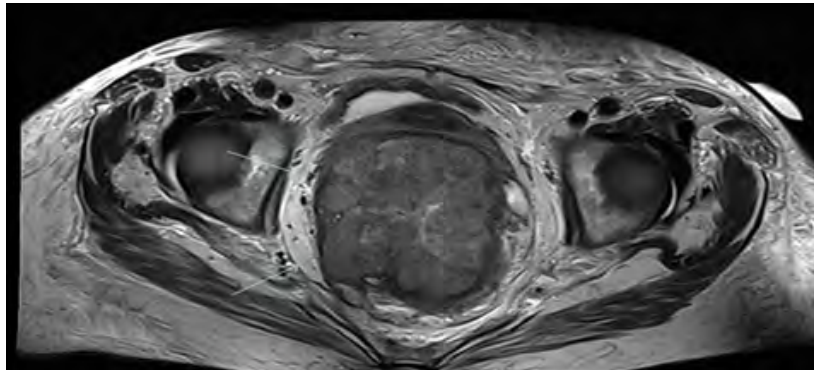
magnetic resonance imaging scan pelvis T2 TSE Axial demonstrating lesion extends to and infiltrates the mesorectal fascia particularly on the right side anteriorly and posteriorly.
